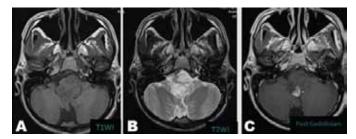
Magnetic resonance imaging (MRI) brain showing an ill defined potine mass which is predominantly isointense to grey matter on T1WI and hyperintense on T2WI with heretogeneous enhancement in post gadolinium with cystic component. This may represent intrinsic pontine glioma commonly found in neurofibromatosis type 1.
